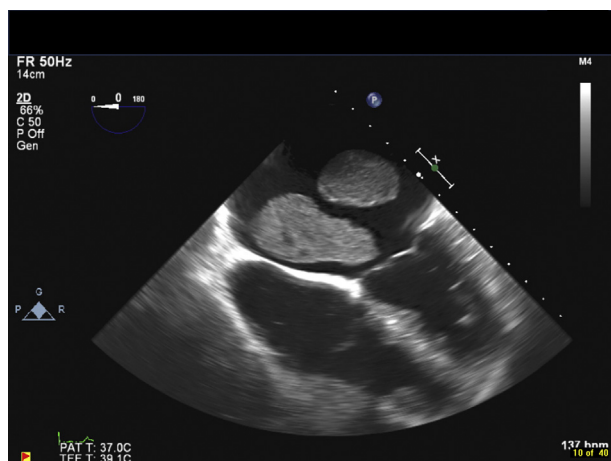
Transesophageal four-chamber view demonstrating two large masses within the enlarged left atrium. The masses appeared freely mobile within the left atrium and to have no apparent attachment to the atrial septum ([Supplemental Video 2](#)).
